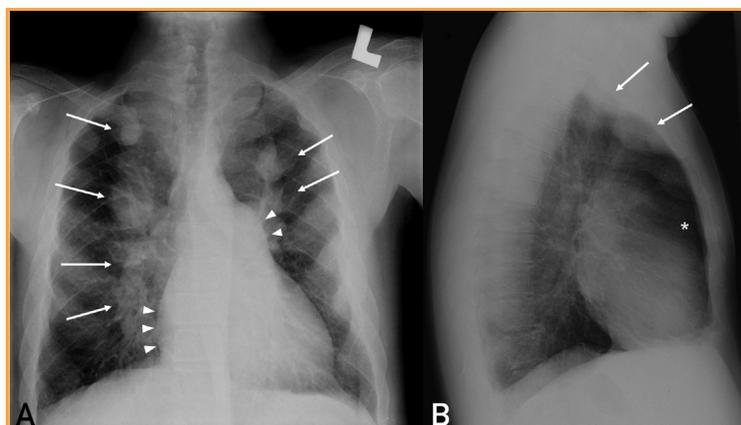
A, Chest radiography in the anterior-posterior projection demonstrating bilateral paravertebral islets of extramedullary hematopoietic tissue (arrows) and prominent pulmonary trunk and right atrium (arrowheads). B, In chest radiography in the lateral projection, extramedullary islets of the anterior chest (arrows) and an enlarged right ventricle (asterisk) are evident.
